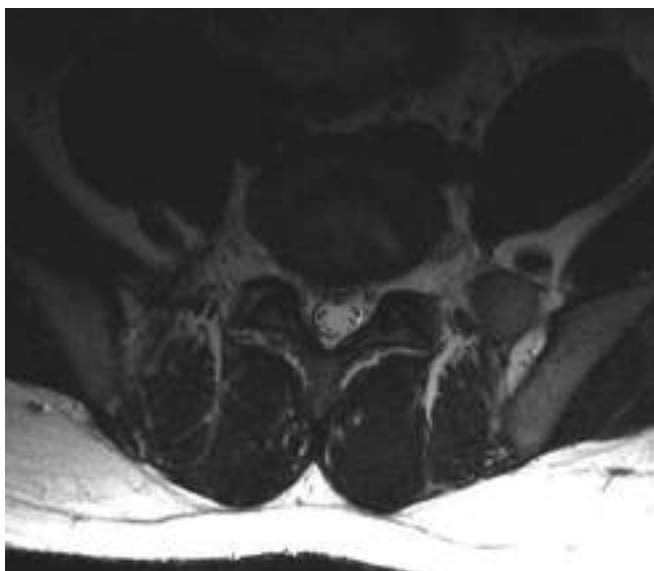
Right L5/S1 disc herniation postoperative MRI
